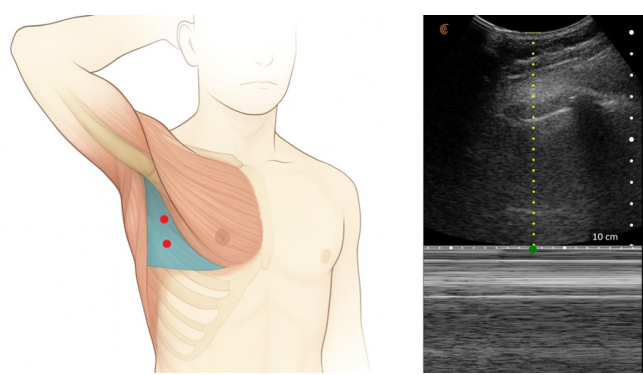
Anatomical landmark and thoracic ultrasound imaging demonstrating the ‘barcode sign’ indicative of pneumothorax with corresponding appropriate intervention site
